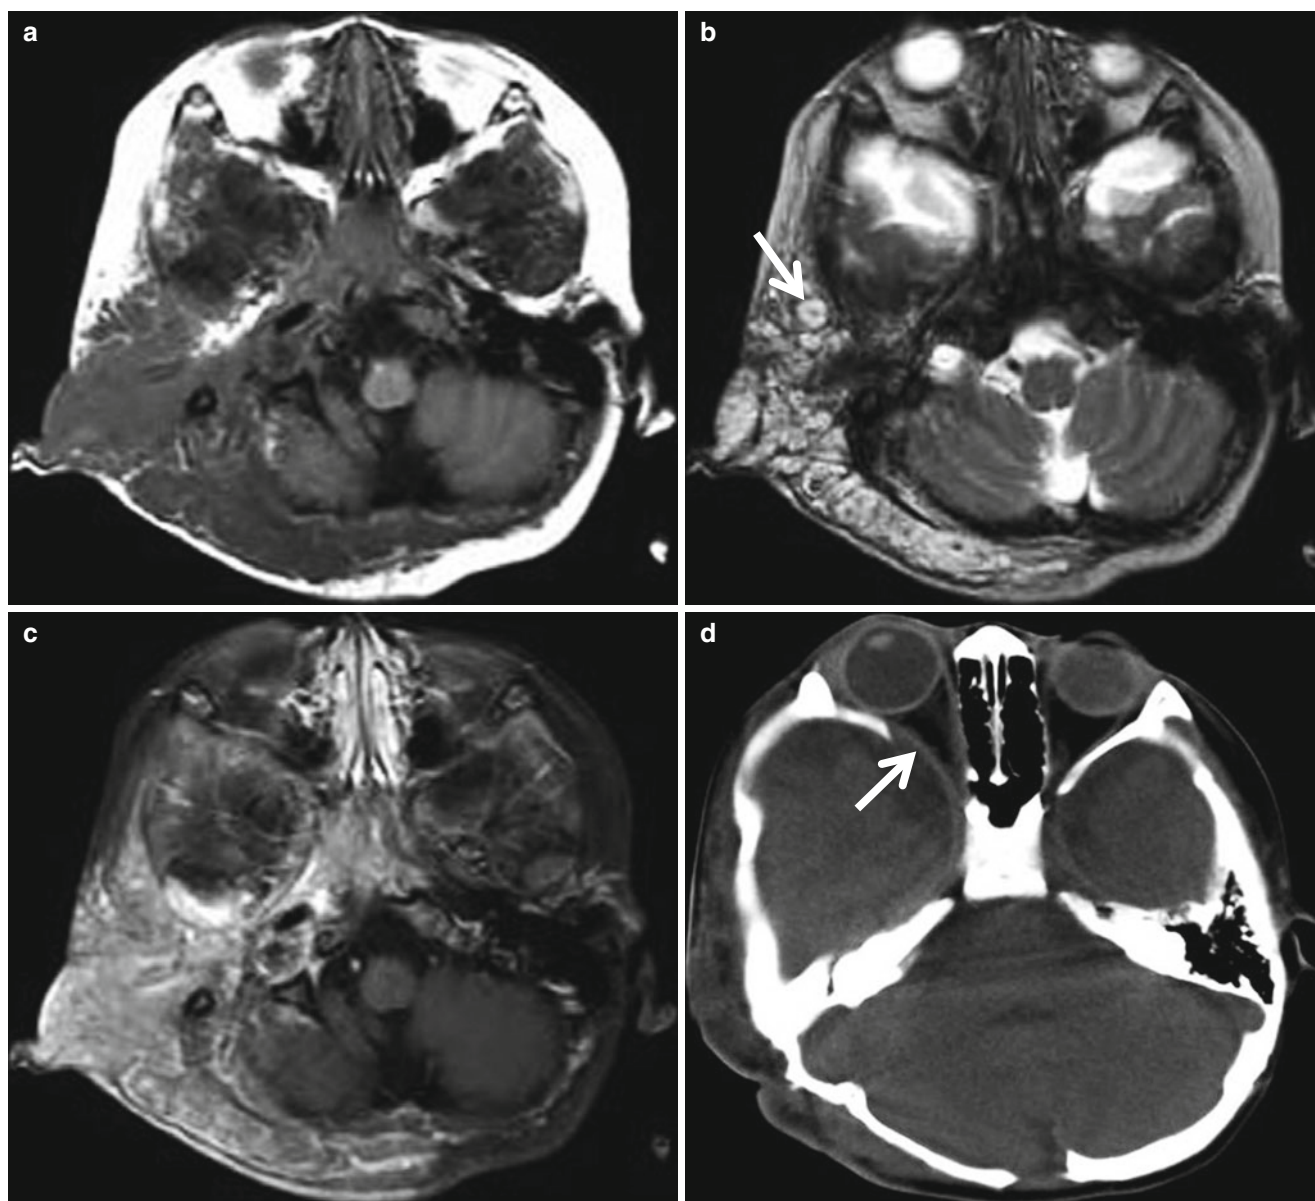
Plexiform neurofibromatosis in a 3-year-old boy with type 1 neurofibromatosis. (a) Axial T1-weighted MR image shows an infiltrating plexiform neurofibromatosis of iso-signal intensity relative to the muscle. (b) Axial T2-weighted MR image shows heterogeneous high signal intensity of the masses with “target sign” (arrow) in some neurofibromas. (c) Contrast-enhanced T1-weighted fat-suppressed MR
